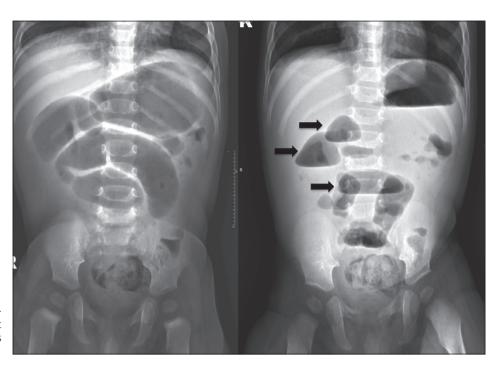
Case 1. Anteroposterior supine Abdominal X-ray (left) and erect position (right). Dilatated bowel loops and air-fluid levels (arrows).
